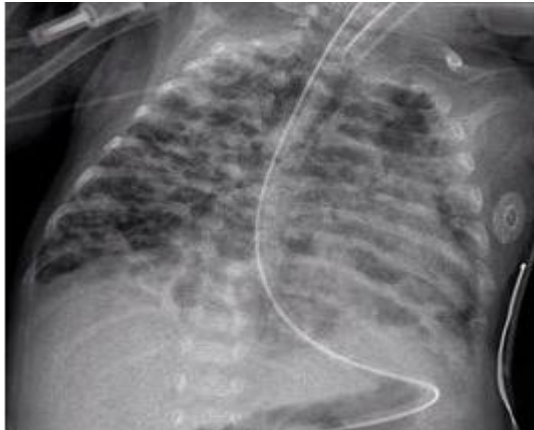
Bronchopulmonary Dysplasia on X-ray
